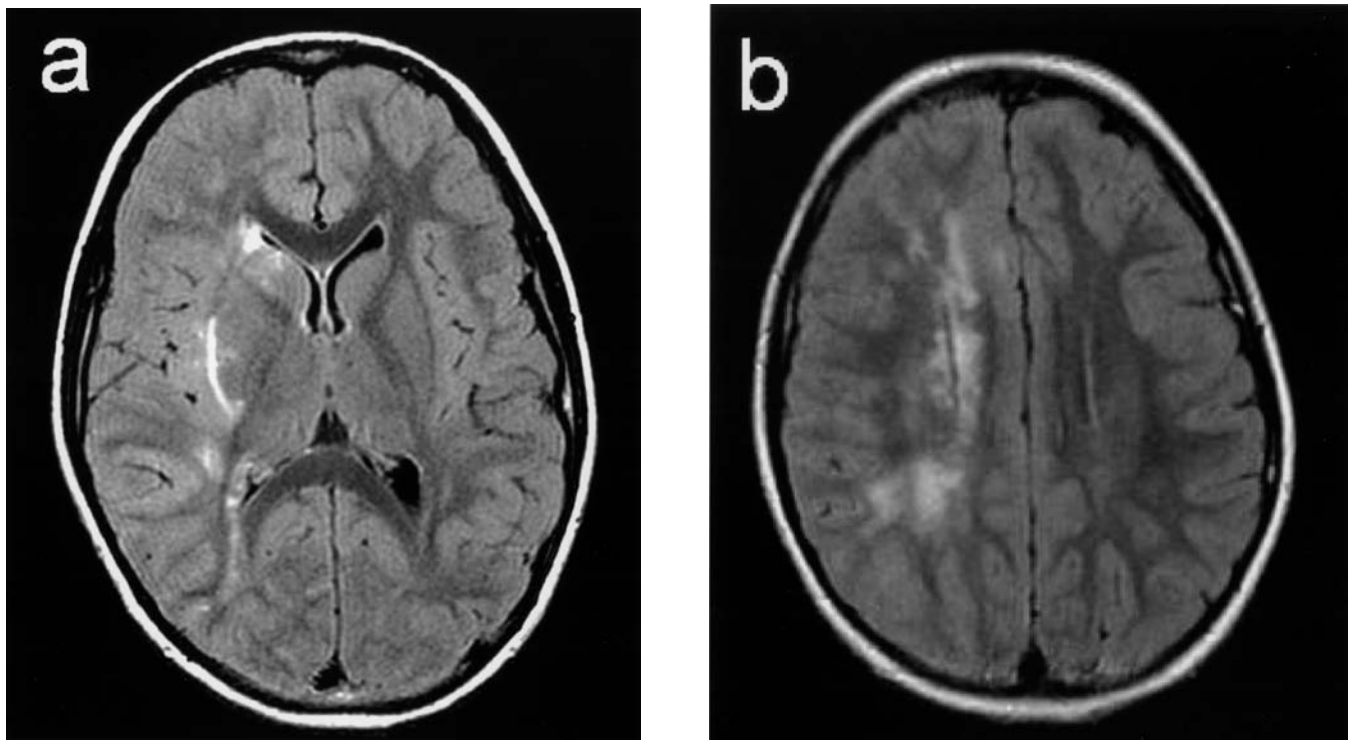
MRI study, Case 2. A. Axial T2 FLAIR (fluid-attenuated-inversion-recovery) image. Multiple sites of T2 hyperintensity in the right hemisphere, including the anterior right caudate head, the right external capsule, and a portion of the right parietal white matter. B. Axial T2 FLAIR image (higher level). Extensive confluent hyperintensity in the white matter of the centrum semiovale of the right hemisphere.
